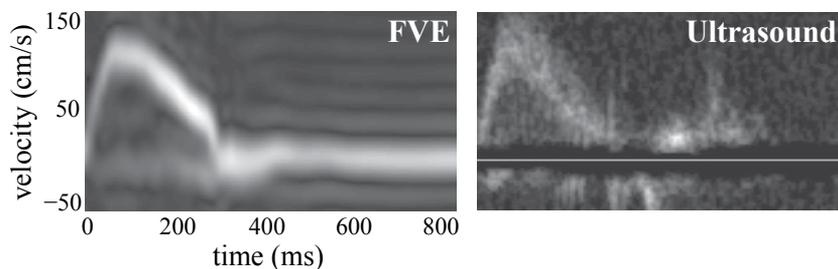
Comparison of the spiral FVE method with Doppler ultrasound, in a healthy volunteer aortic valve study.
